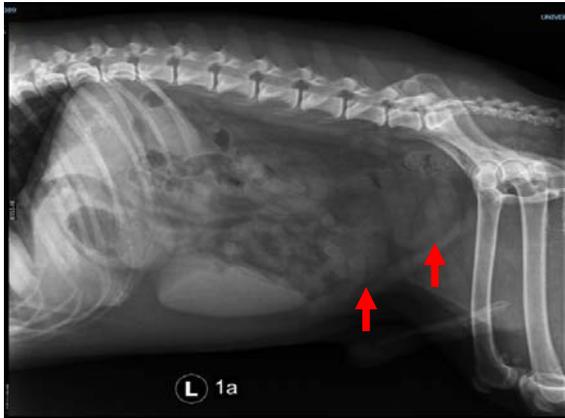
Left lateral view of abdominal radiograph revealed two oval radiopaque structures on caudal region of the abdominal cavity (arrow).
